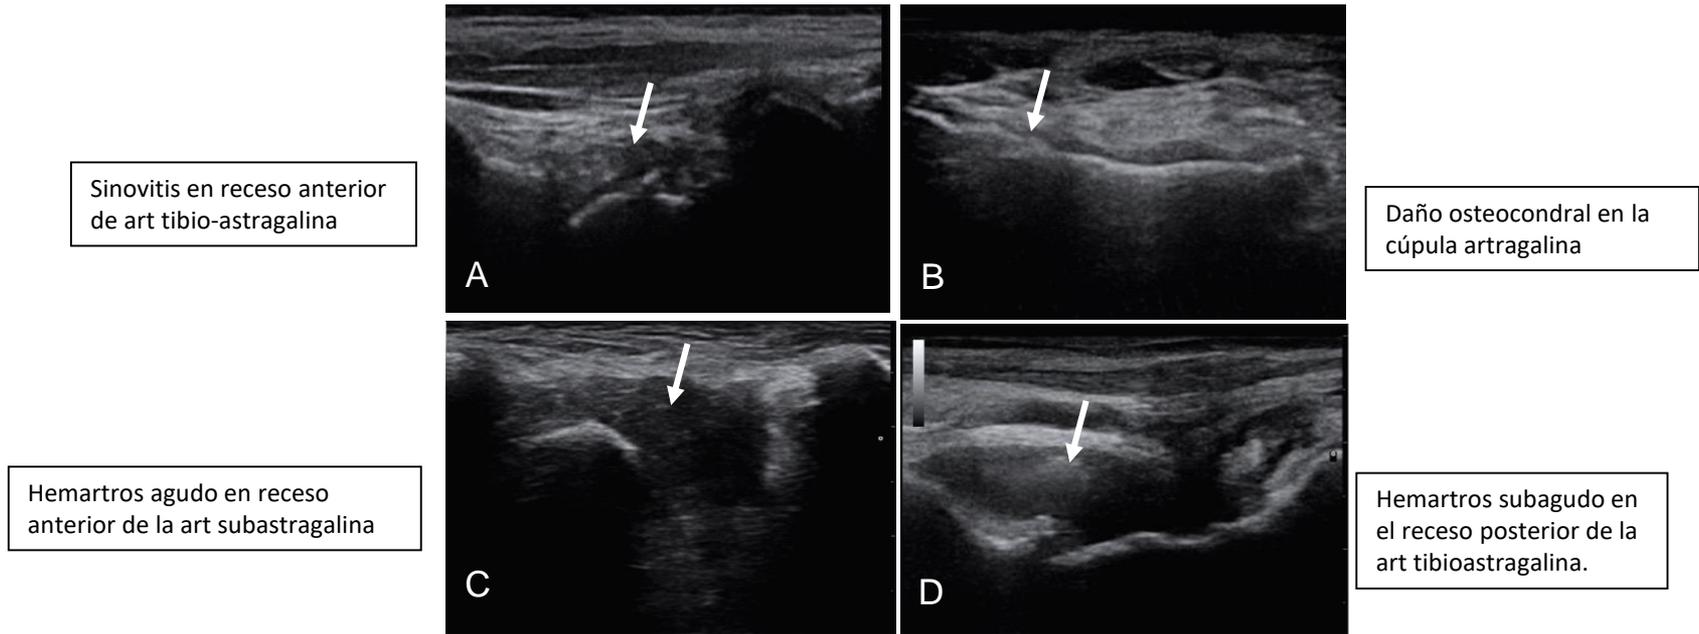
Ultrasound abnormalities according to Haemophilia Joint Health Scores.
